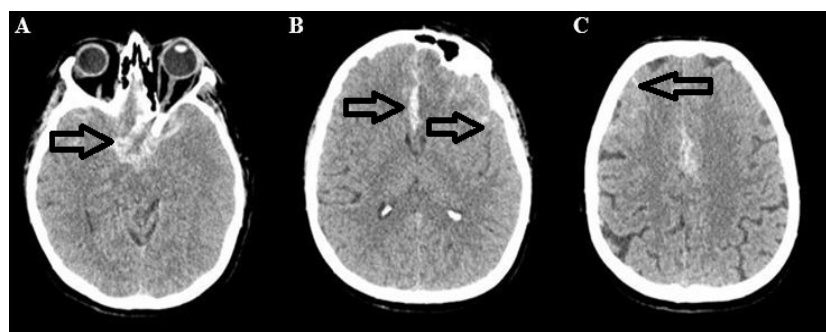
Non-contrast axial computed tomography indicates spontaneous subarachnoid hemorrhage (marked by arrows) extending into the basal and suprasellar cisterns (A), into the proximal Sylvian fissure and the anterior part of the interhemispheric fissure (B), reaching the right frontal convexity (C).
